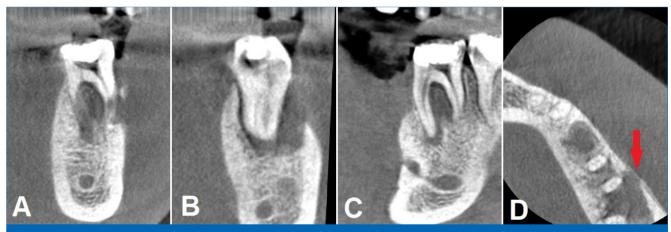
CBCT examination of tooth 36. A) coronal view of the mesial root; B) coronal view of the distal root; C) sagittal view; D) axial view, the red arrows mark the endodontic-periodontal lesion.
